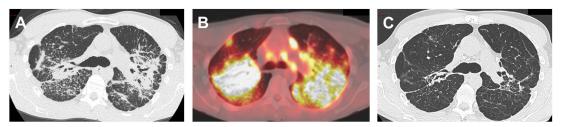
A 50-year-old man with fibrotic pulmonary sarcoidosis with a pattern of distortion and mixed ventilatory defect. HRCT scans show a pattern of distortion in the upper lobes, with posterior and superior displacement of the main bronchus and angulated and deformed airways (*A*, *C*). Superimposed peribronchovascular and septal thickening, ground-glass opacification and nodules suggest the presence of persistent granulomatous activity (*A*), which was confirmed by the intense uptake of ¹⁸FDG on PET/CET (*B*). The features of granulomatous activity were reversible under treatment (*C*).
